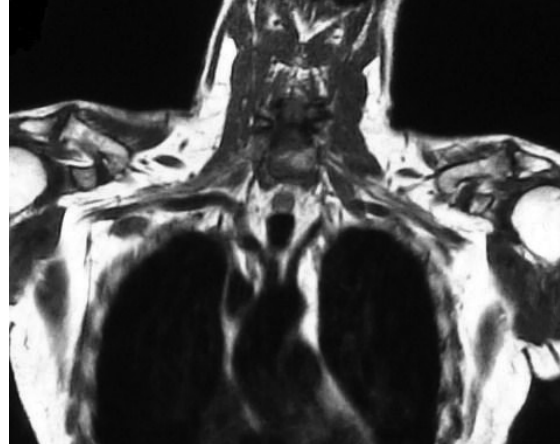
Coronal T1-W MR image of both shoulders shows the well-formed coracoclavicular joints between the lateral end of clavicle and coracoid process bilaterally.
